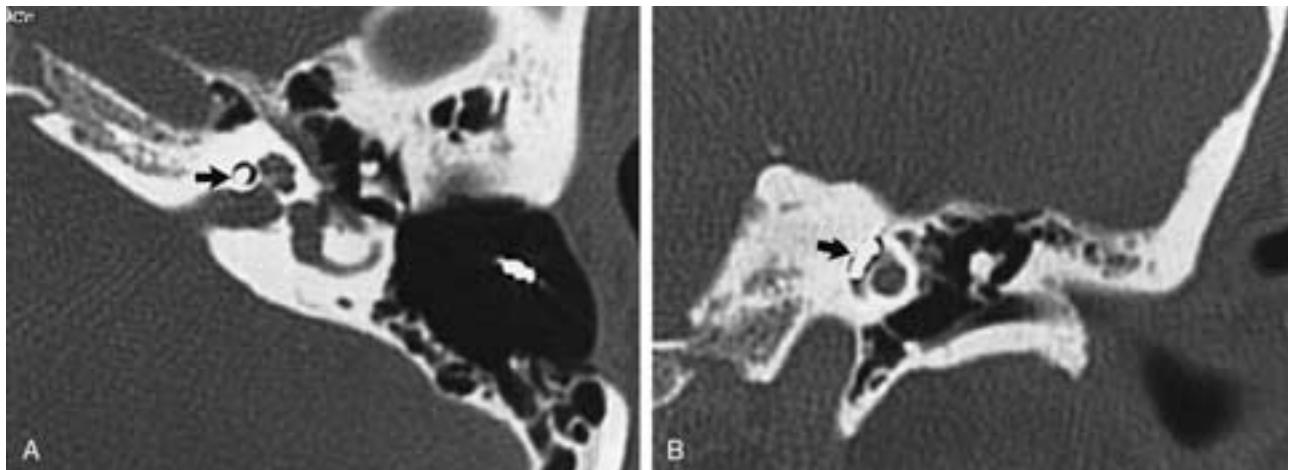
Multichannel cochlear implant. Axial (A) and coronal CT (B) images show a metallic device (*arrow*) in the basal turn of the cochlea.
